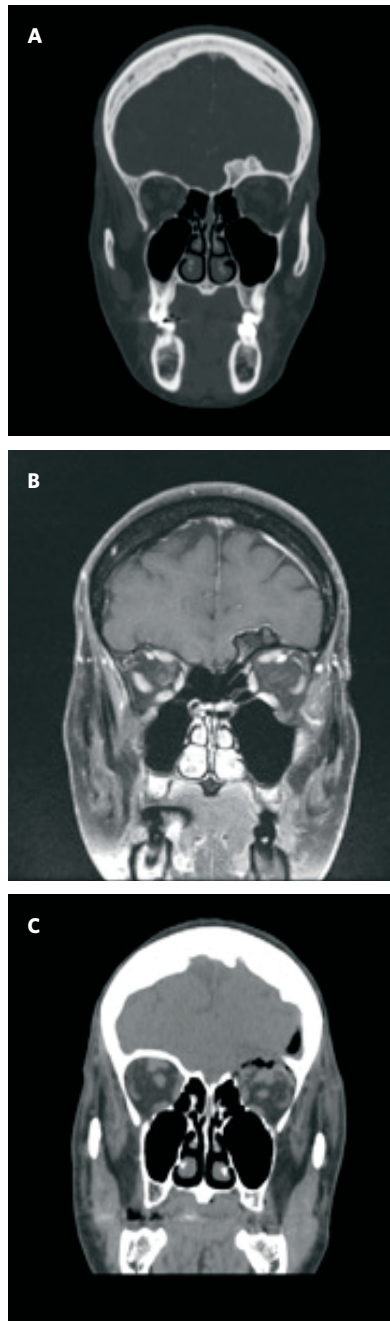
(A) Preoperative coronal CT shows the tumor growing in the bone of the roof of the orbit. (B) Preoperative coronal MRI with contrast shows the tumor (dark) with surrounding dural involvement, typical for a meningioma. (C) Postoperative coronal CT shows complete removal of the bony tumor and surrounding involved dura.
